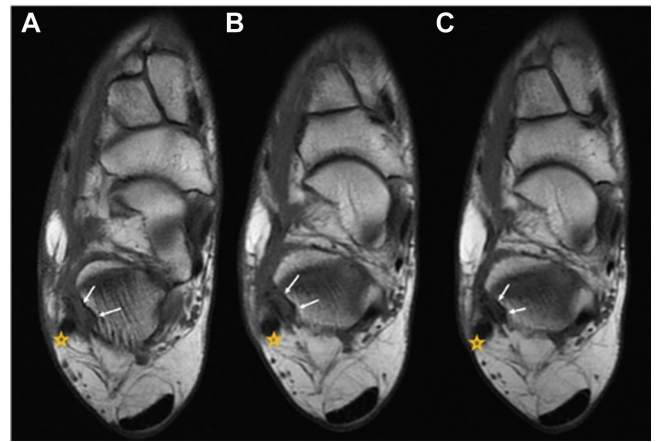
T1-weighted axial view of the ankle at (A) 6 months, (B) 12 months, and (C) 24 months after anatomic lateral ankle ligament reconstruction showing the morphological/signal magnetic resonance imaging evolution of the CFL graft—the CFL graft (white arrows) and the peroneus longus tendon (stars). CFL, calcaneofibular ligament.
